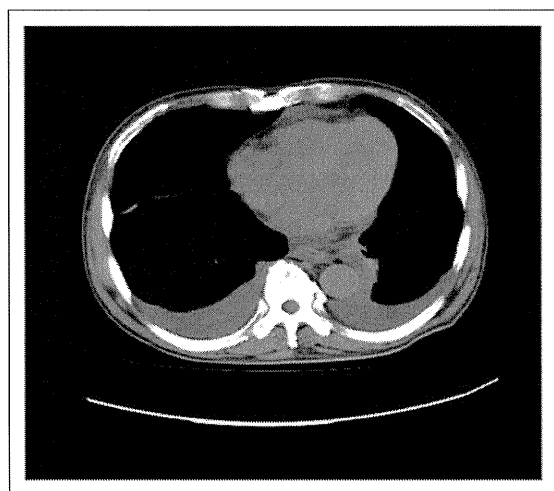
Computed tomographic scan at the onset of disease. Note massive bilateral pleural effusion. Case 7.
